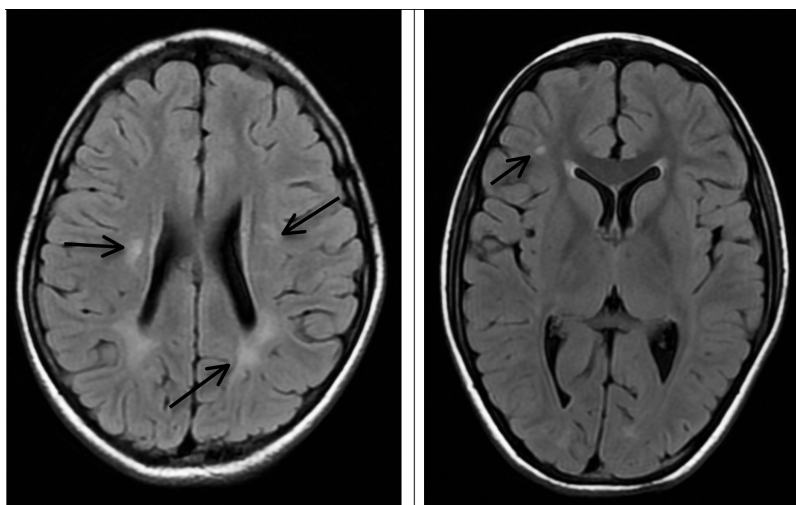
FLAIR images showing hyper intensities in bilateral centrum semiovale and periventricular white matter (left) and right frontal subcortical white matter (right) (ARROWS)
